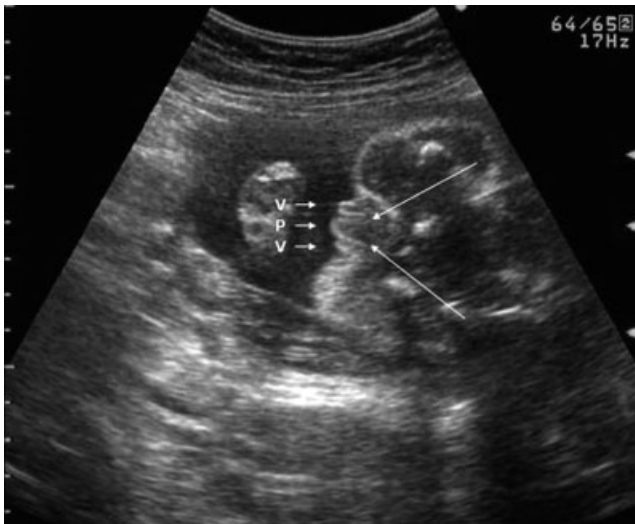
Coronal section of ultrasound image showing a mass bulging out of the vaginal canal. The covering of the protruding mass (P) is continuous with the lining of the vaginal wall. The long arrows mark the reflexion of the vaginal wall. V, vulva.
